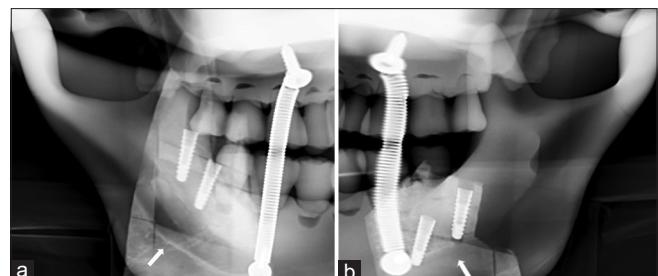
(a) Cropped panoramic radiographs of control implants, and (b) cropped panoramic radiographs of implants with pilot drill injury to the inferior alveolar nerve canal (right implant) and penetration of the inferior alveolar nerve canal (left implant). Arrows point to inferior alveolar nerve canal.
